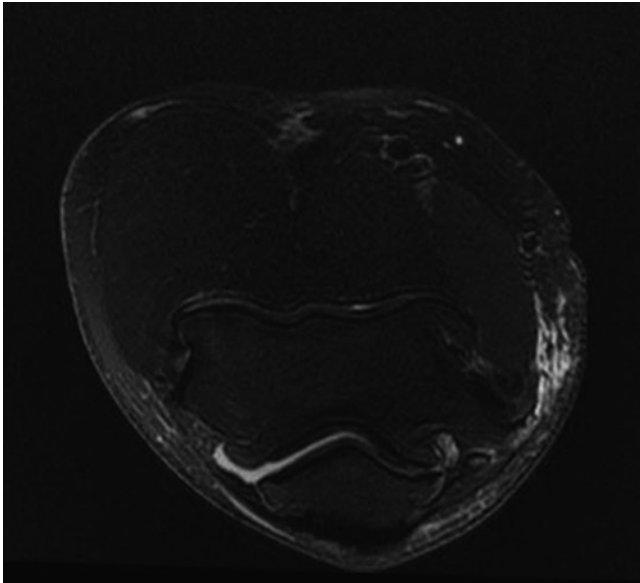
Axial T2 MRI again demonstrating osteophytes lining the olecranon fossa with corresponding osteophytes along the periphery of the olecranon
